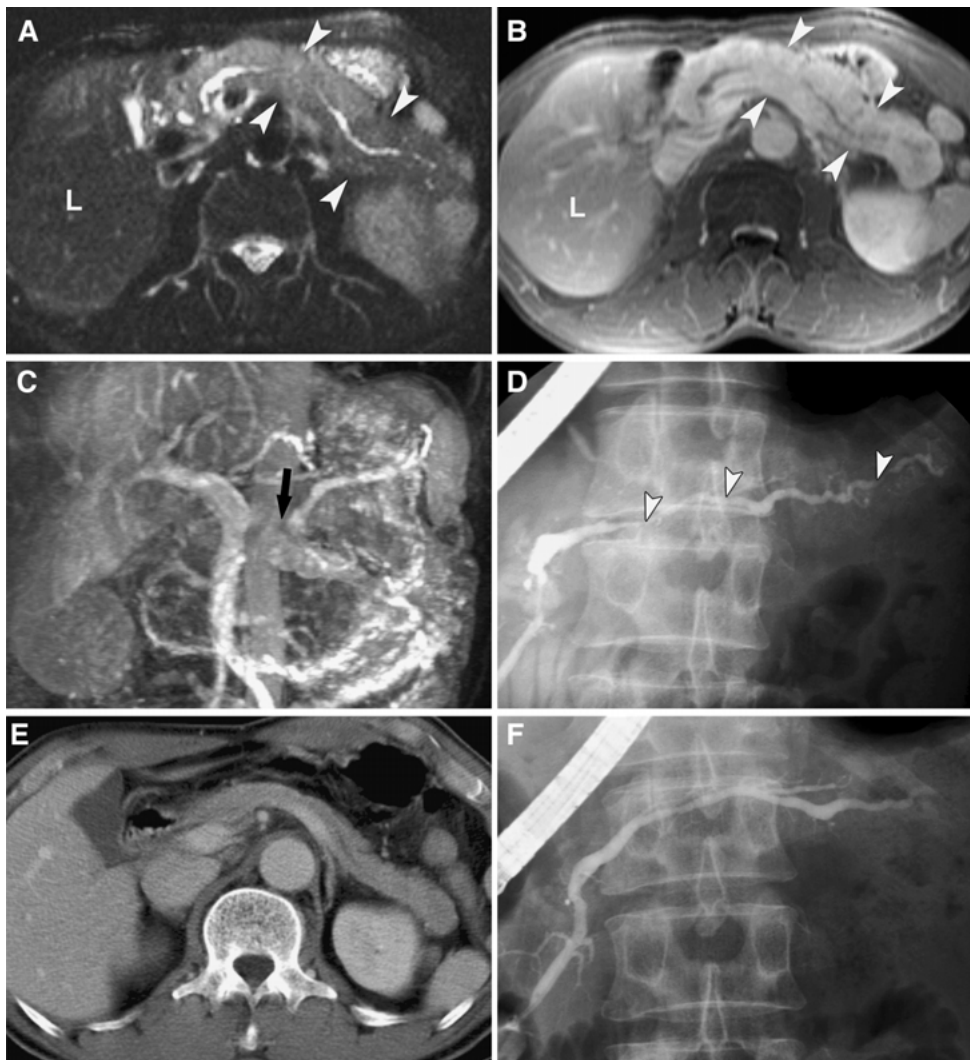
AIP in a 61-year-old man that presented as a palpable abdominal mass for 6 months. A Transverse T2-weighted MR image shows diffuse enlargement of the pancreas (*arrowheads*). Note the high signal intensity of the pancreatic parenchyma compared with that of liver (*L*). B Contrast-enhanced MR image shows stronger enhancement of the pancreatic parenchyma (*arrowheads*) compared with the liver (*L*). C Maximal intensity projection image generated from MR angiography during the PVP shows severe narrowing of the splenic vein (*arrow*). D ERCP image shows multiple narrowings of the main pancreatic duct (*arrowheads*) involving all segments of the pancreas. E On contrast-enhanced CT obtained 2 months after steroid therapy, enlargement of the pancreas has decreased. F On follow-up ERCP obtained 2 months after steroid therapy, narrowing of the pancreatic duct has decreased.
